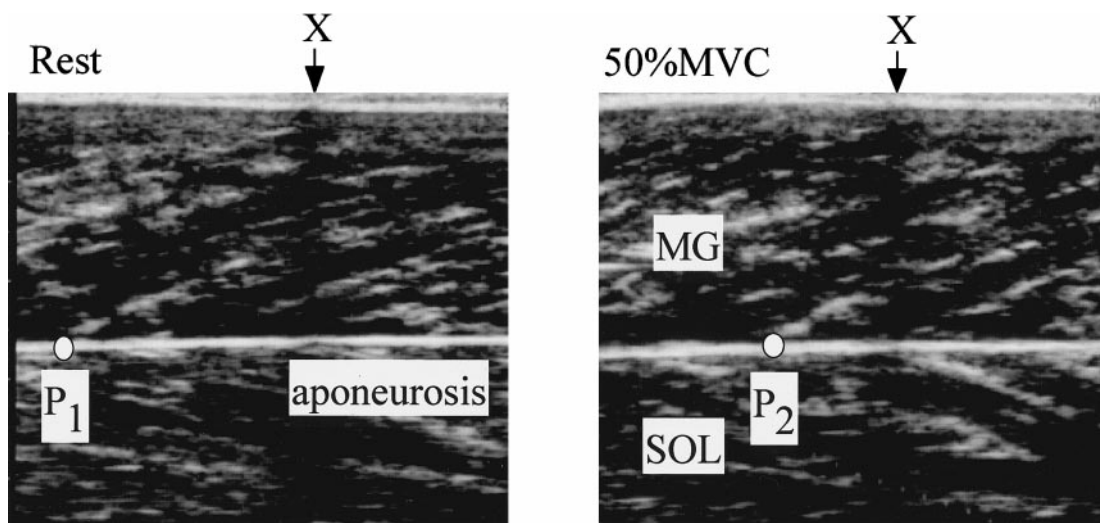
Ultrasonic images of longitudinal sections of MG muscle during isometric contraction. A marker (X) was placed between the skin and the ultrasonic probe as the landmark to confirm that the probe did not move during measurements. The cross-point (P) between superficial aponeurosis and fascicles did not move. P was determined from the echoes of the deep aponeurosis and fascicles. P moved proximally during isometric torque development from rest (P_1) to 50% of maximal voluntary contraction (50%MVC; P_2). The distance traveled by P (L) was defined as the length change of tendon and aponeurosis during contraction.
